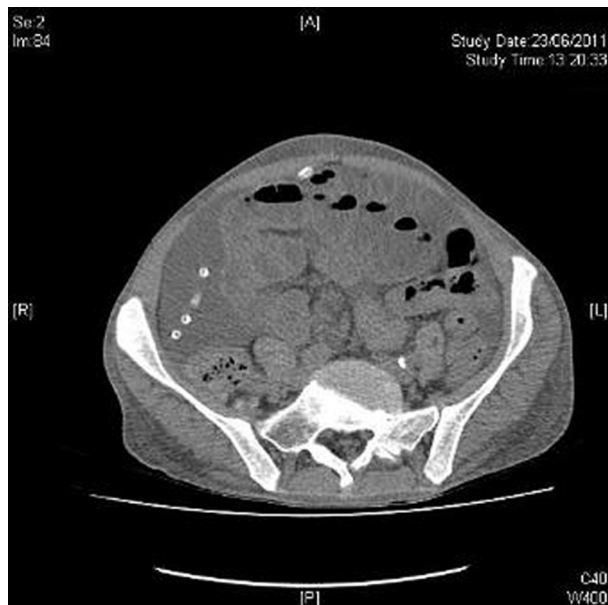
Non-contrast CT showing dilated bowel loops with continuous ambulatory peritoneal dialysis catheter.
